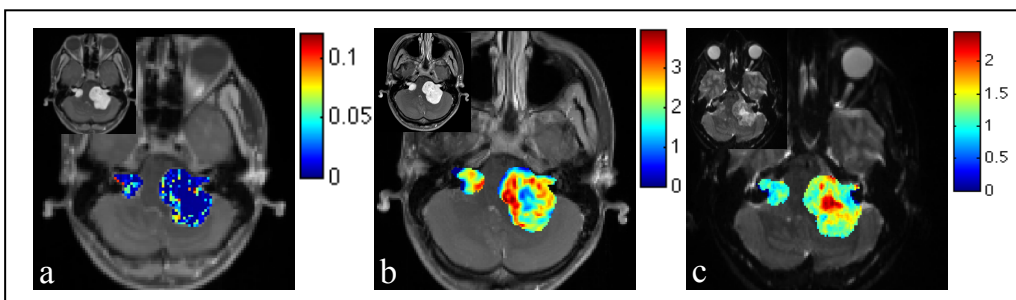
a) DCE-MRI derived K^{trans} map (min⁻¹); b) DSC-MRI derived rCBV map (unitless); c) ADC map (mm²/s).
